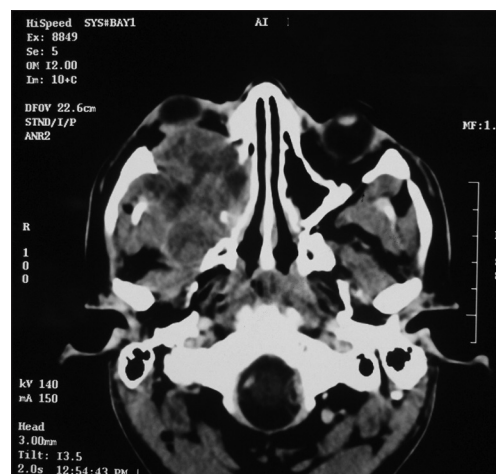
Axial computed tomography image showing enhancing mass lesion in right maxillary sinus extending into infratemporal fossa, pterygoid plates, right orbit
